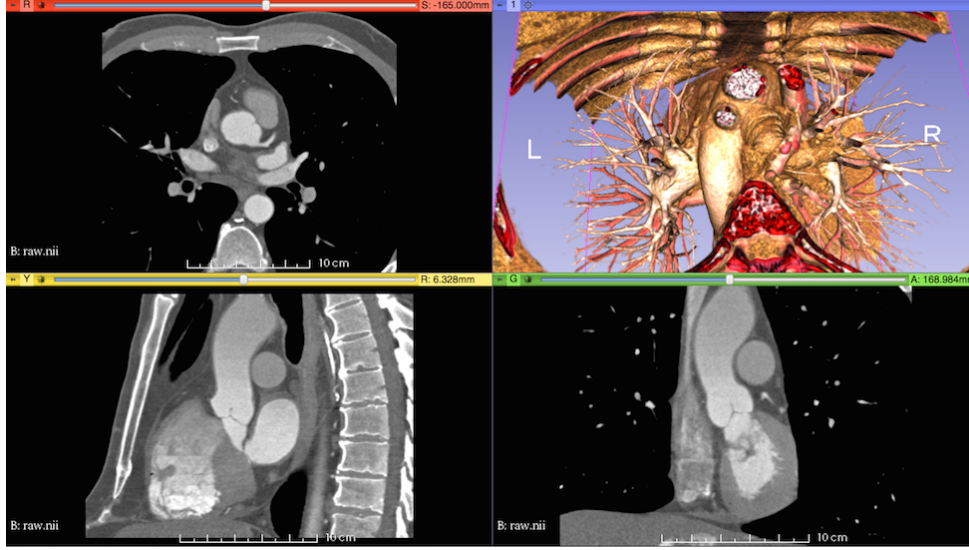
The computed tomography (CT) image data used in this study.
